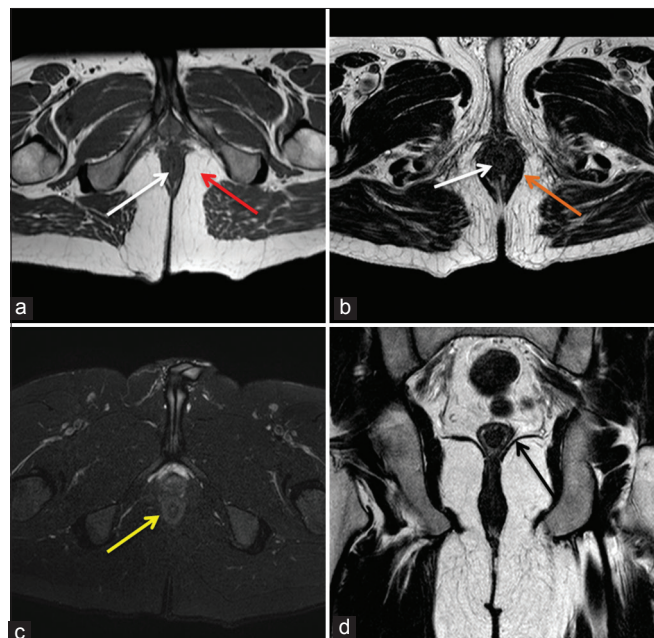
(a) Axial T1-weighted image shows the normal hypointense internal anal sphincter (white arrow), and the ischiorectal fossa (red arrow). (b) Axial T2-weighted (T2W) image shows the normal hypointense external (orange arrow) and internal anal sphincters (White arrow). (c) Axial proton density image shows the hyperintense normal internal sphincter (yellow arrow). (d) Coronal T2W image shows the normal levator ani muscle (black arrow)
